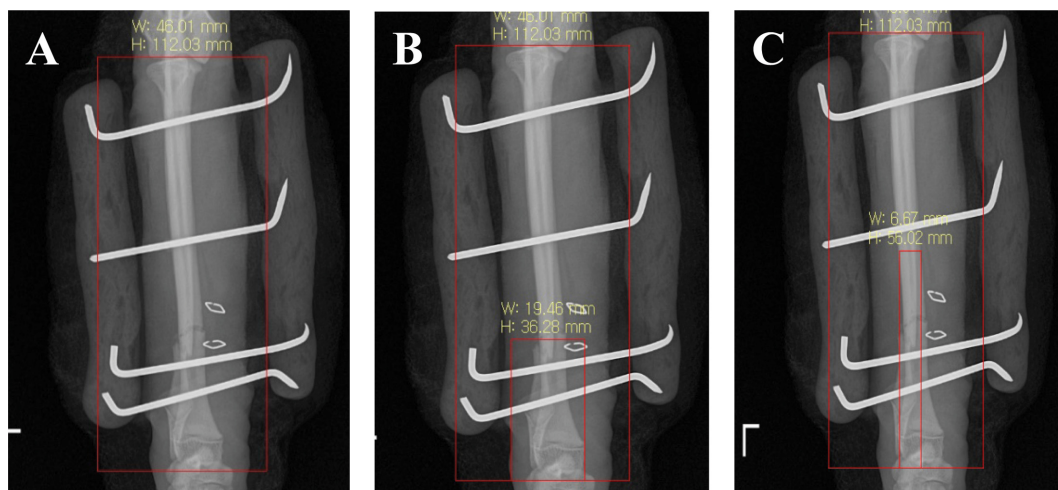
Measurement of morphometry of the radius and location of the fracture line in radiographs. (A) Anteroposterior postoperative radiographic images were used. The maximum length of the radius (MLR) is measured from the most proximal end on the radial head to the tip of the styloid process (112.03 mm). (B) The distance of the fracture line from the styloid process (FLS) is measured from the tip of the styloid process to the most distal fracture line (36.28 mm). (C) The transverse diameter at midshaft (TDM) is the distance from the medial to the lateral surface of the midshaft (6.67 mm).
